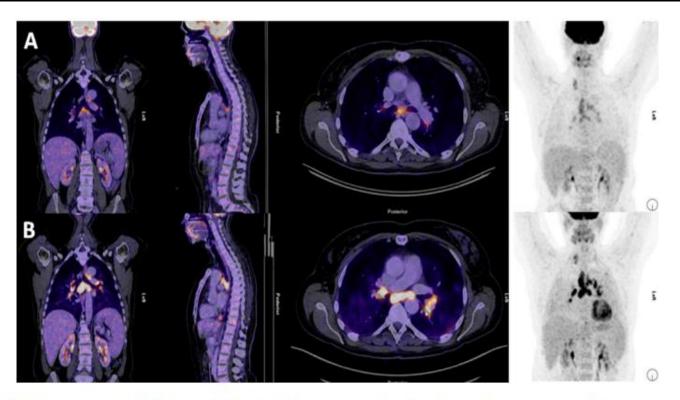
Fifty-five year-old female with Mantel cell lymphoma of the milt in the history, presenting with B symptoms (fever and weight loss) and high suspicion of transformed NHL. [A] [18F]FDG-PET/CT shows multiple enlarged and highly [18F]FDG-avide lymph nodes in the mediastinum and right supraclavicular. Due to the symmetrical uptake sarcoid like reaction was part of the differential diagnosis but recurrent lymphoma could not be ruled out. Pathology results of lymph nodes 4R and 11R (via EBUS) showed granulomatous inflammation. [B] Follow-up scan 10 weeks later show decreased [18F]FDG-uptake in all nodes, confirming self-limiting sarcoid like reaction.
